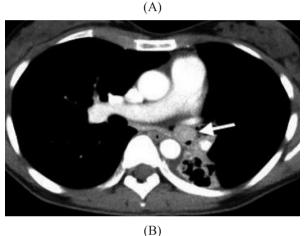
Computed tomography of the chest showed a suspicious mass-like lesion in the left main bronchus, near the left secondary carina.
